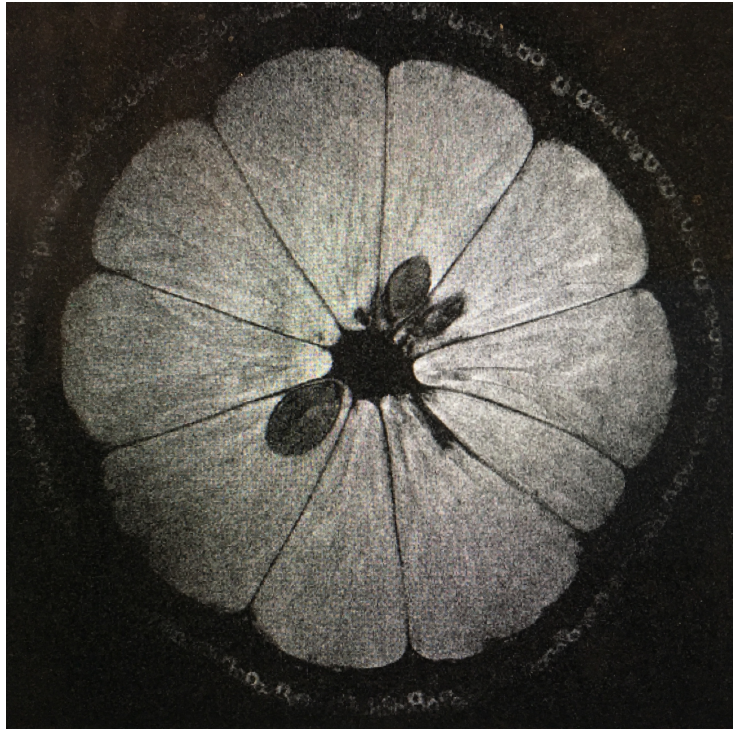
^1H MRI image of an orange, the difference in ^1H spin density (corresponding to H_2O content) between flesh and pith can clearly be seen.
